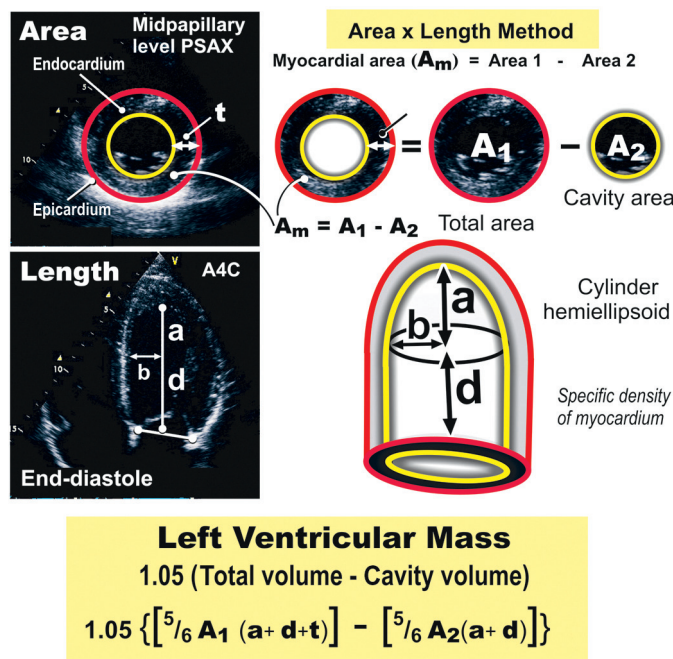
LV mass calculation in two-dimensional echocardiography using an area-length method for a cylinder hemiellipsoid. Area 1 (A_1) is the total planimetered area at the mid-LV level on the parasternal short-axis (PSAX) view; area 2 (A_2) is the planimetered LV cavity area; A_m is the myocardial "shell" area; b = minor axis radius; t = wall thickness. (Modified from Bulwer BE, Rivero J, Solomon SD: *Basic principles of echocardiography and tomographic anatomy*. In Solomon SD [ed]: *Atlas of Echocardiography*. 2nd ed. Philadelphia, Current Science/Springer Science, 2009, pp 1-24.)
